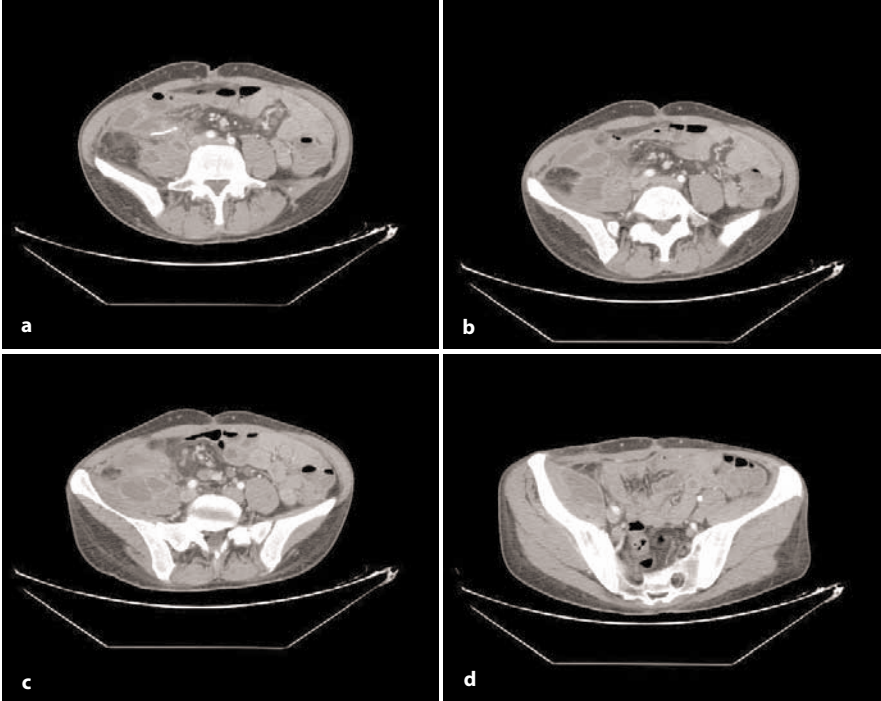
Patient (A). Patient with CD, undergone surgery for ileo-colitis. Transverse CT images obtained at the level of ileo-psoas muscle, shows deep pelvic abscess
